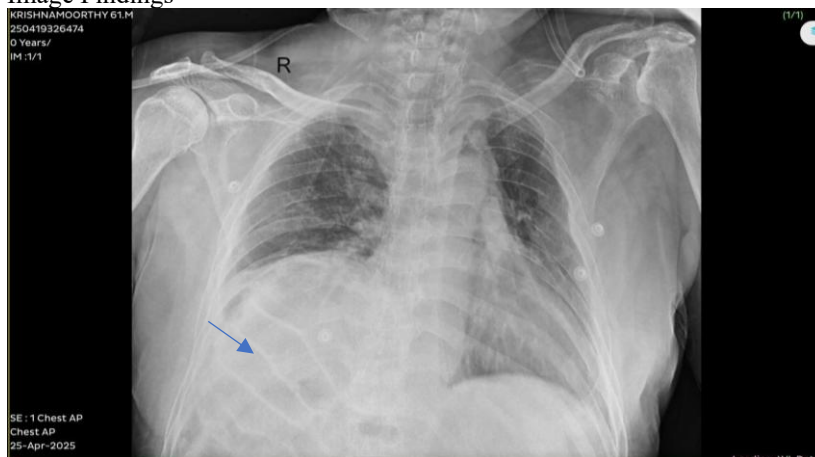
CHEST X-RAY SHOWING DILATED BOWEL LOOPS UNDER RIGHT HEMIDIAPHRAGM
